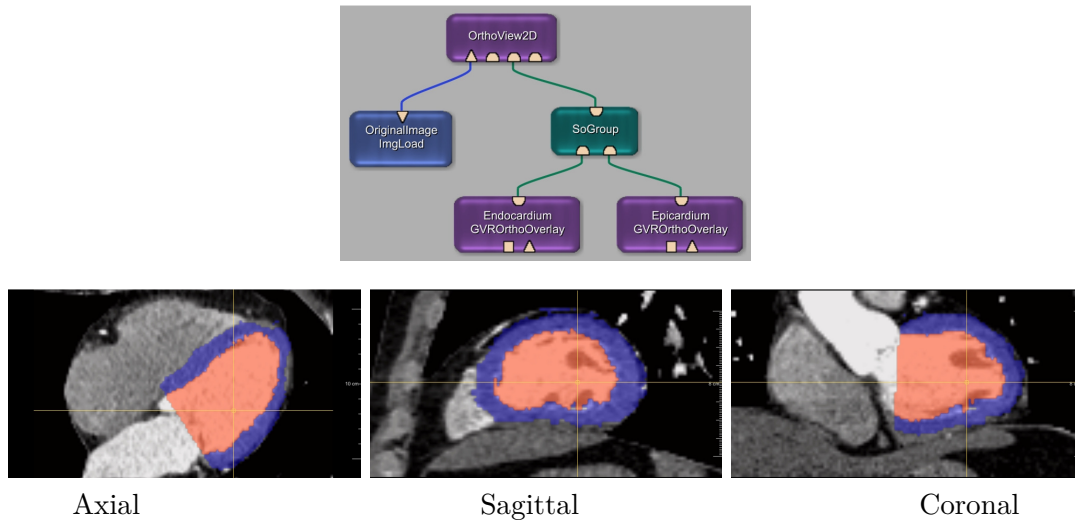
Top, basic module network to accomplish image visualization with the segmented regions shown over the CT image using transparency; bottom, three orthogonal views of a cardiac CT volume and corresponding segmentations.
